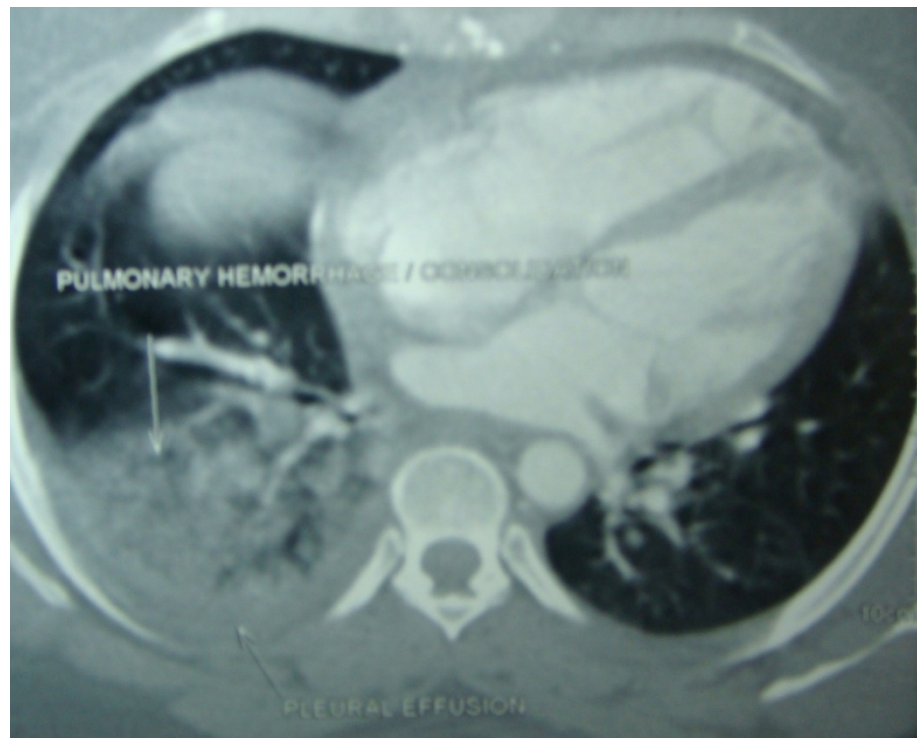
CT thorax of same patient with pulmonary hemorrhagic infarction and Rt pleural effusion.
